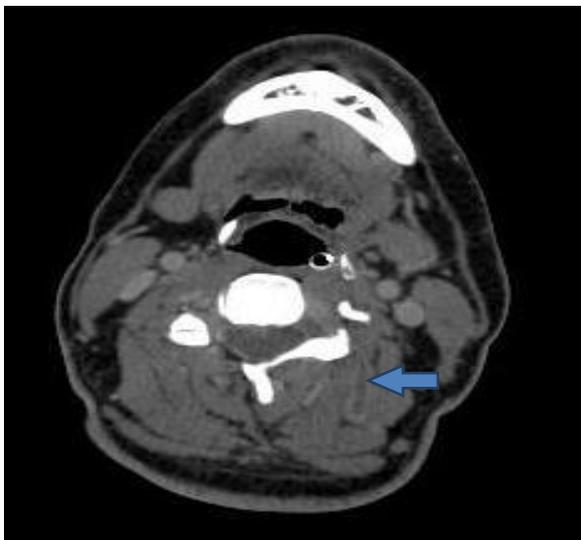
axial CT SCAN SHOWING left paravertebral vein thrombosis
